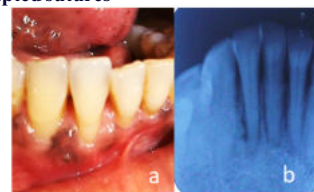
Post-operative 1 year a) Clinical view b) Radiographic view
